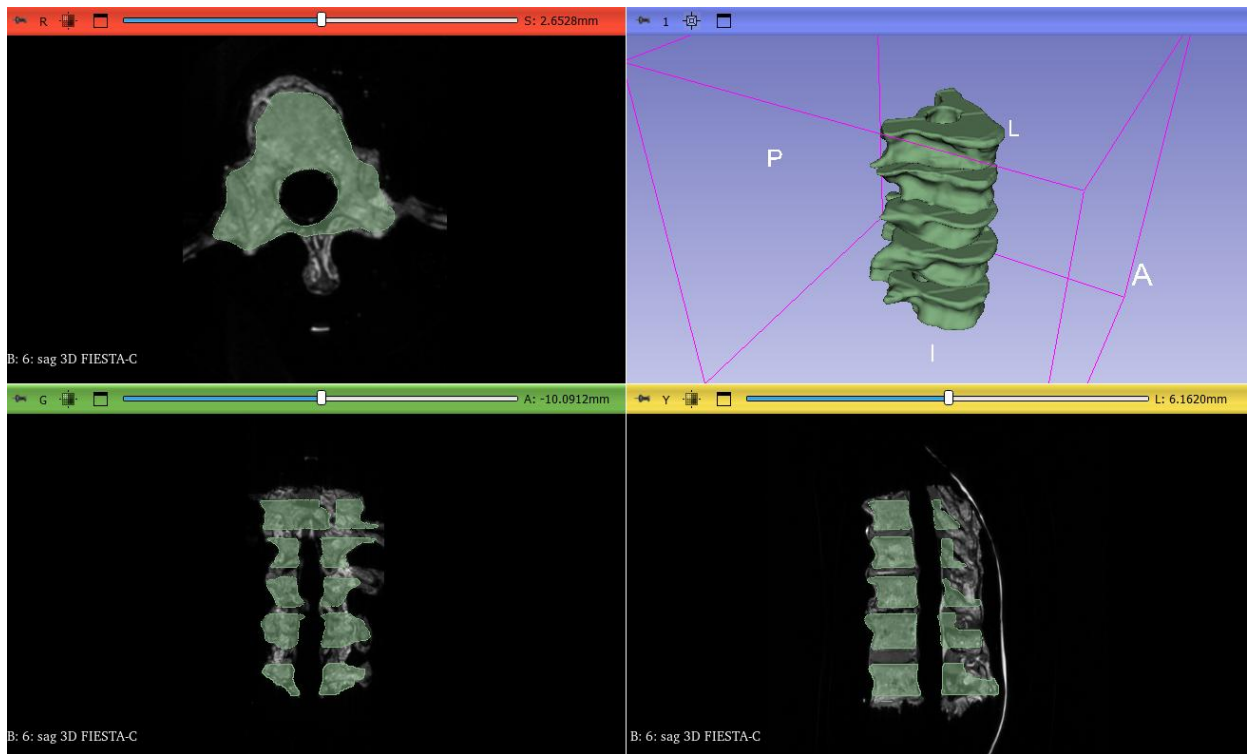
final vertebrae segmentation from MRI images
